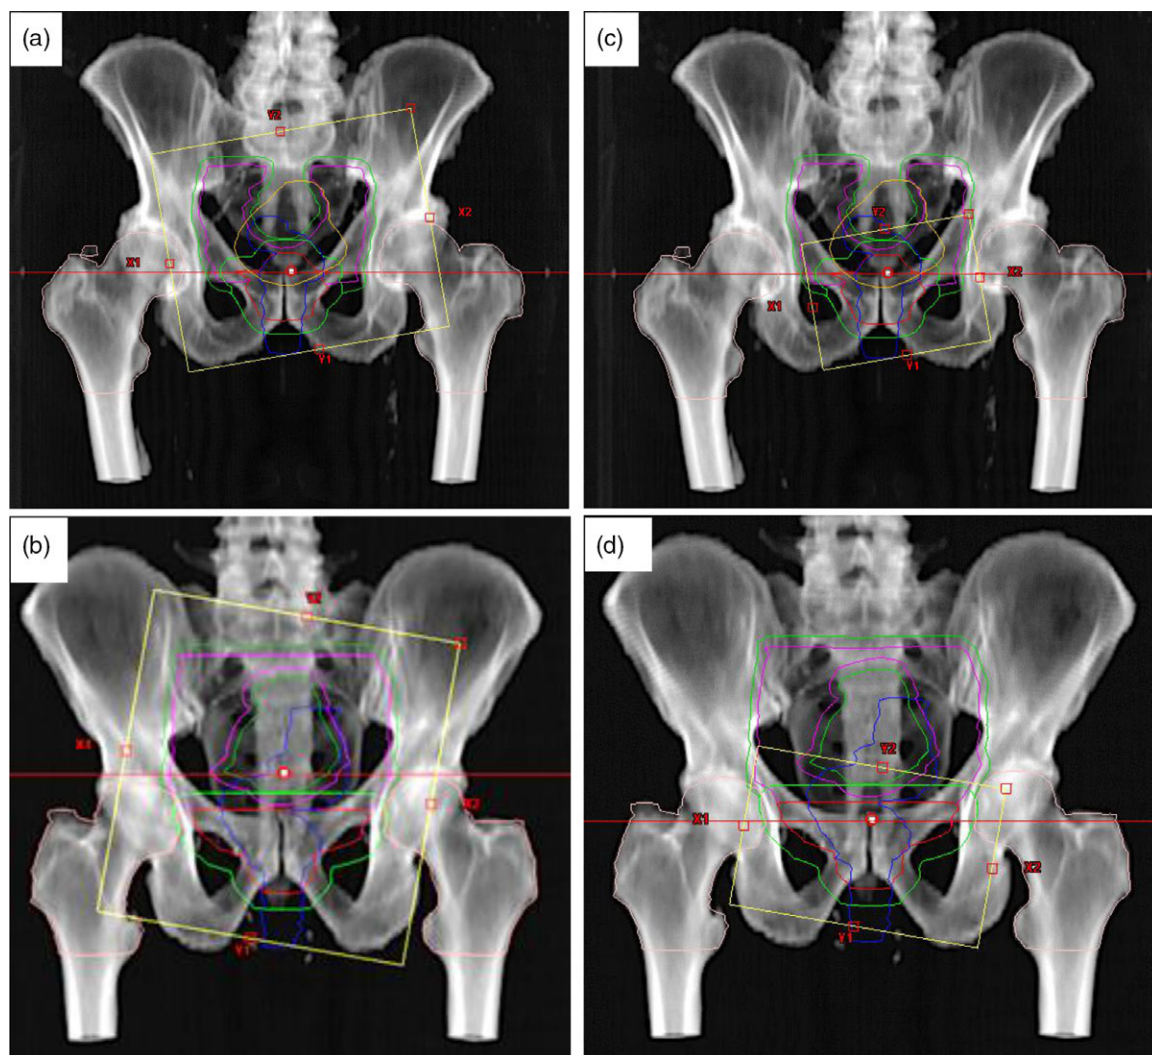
Digital reconstructed radiographs (DRR) showing the field placements when treating the whole pelvis for intact prostate (a) and post prostatectomy prostate bed (b) patients and the boost field for the intact prostate (c) and prostate bed (d). CTV-primary (prostate or prostate bed) = red, CTV-Pel (primary plus nodes) = magenta, PTV-primary (prostate plus margins) = green, PTV-Pel (prostate plus nodes plus margins) = dark green, bladder = orange, rectum = blue, femur heads = pink.
